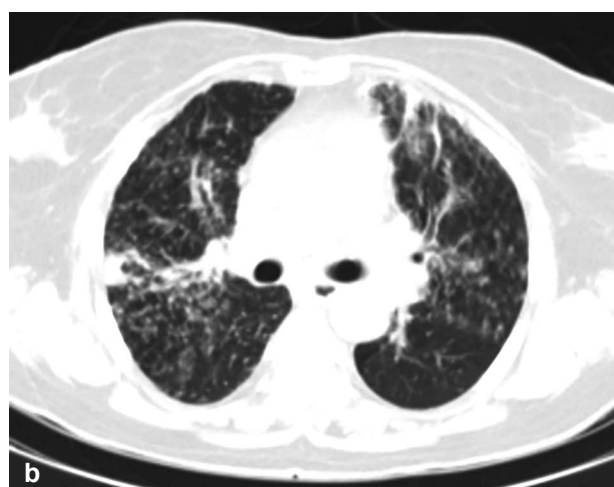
It showed thorax CT scan.
